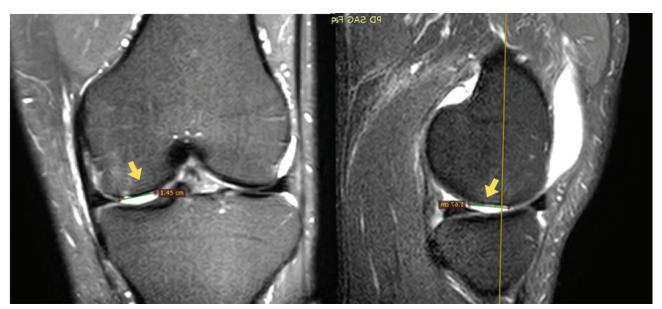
Preoperative magnetic resonance imaging showing full-thickness cartilage defect on the medial femoral condyle Slika 2. Preoperativna magnetska rezonancija koja pokazuje defekt hrskavice pune debljine na medijalnom femoralnom kondilu
